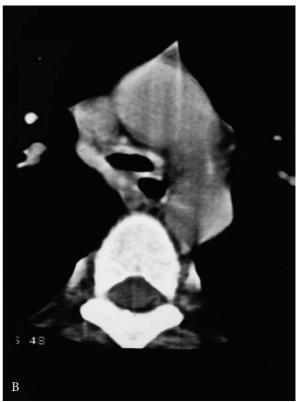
Tracheopathia osteochondroplastica. A, Anteroposterior tomogram reveals diffuse nodularity of the trachea and bronchi. B, Computed tomography scan at the level of the midtrachea demonstrates thickening and nodularity of the tracheal cartilage, sparing the membranous wall.
